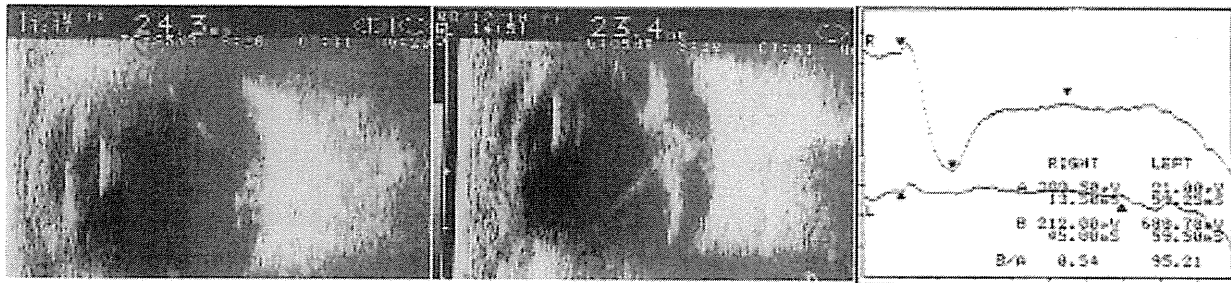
Ultrasound echograms of the right (left) and left (middle) eyes showing vitreoretinal adhesions in the posterior pole. In the left eye, proliferative tissue and tractional retinal detachment can be seen. Single-flash electroretinogram (right) showing attenuated *b* wave and normal *a* wave resulting in a negative-type electroretinogram in the right eye and no response in the left eye.
